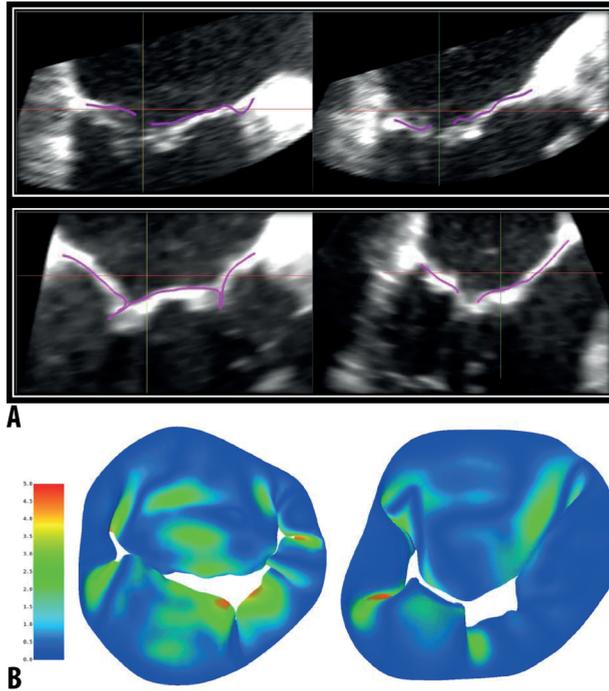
Qualitative and quantitative comparison with true echocardiographic imaging
